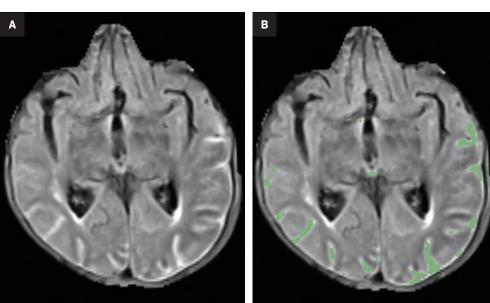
ARIA-E (sulcal effusion) on axial FLAIR involving the bilateral temporal and occipital regions without (A) and with Al-based segmentation (green, B).
